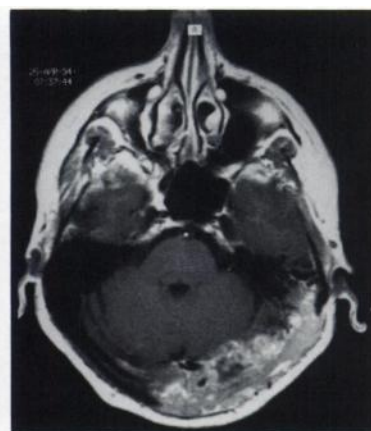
Brain MR image depicts a bony metastatic lesion.
